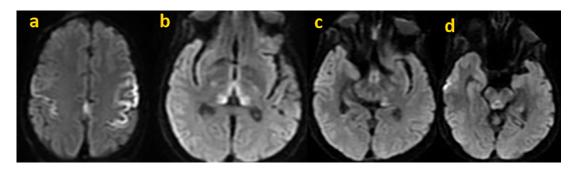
Axial section of MRI in diffusion sequence B1000: signal abnormalities on parietal cortex (a), in, medial thalamus (b), in periaqueductal area and the mammillary bodies (c, d).
